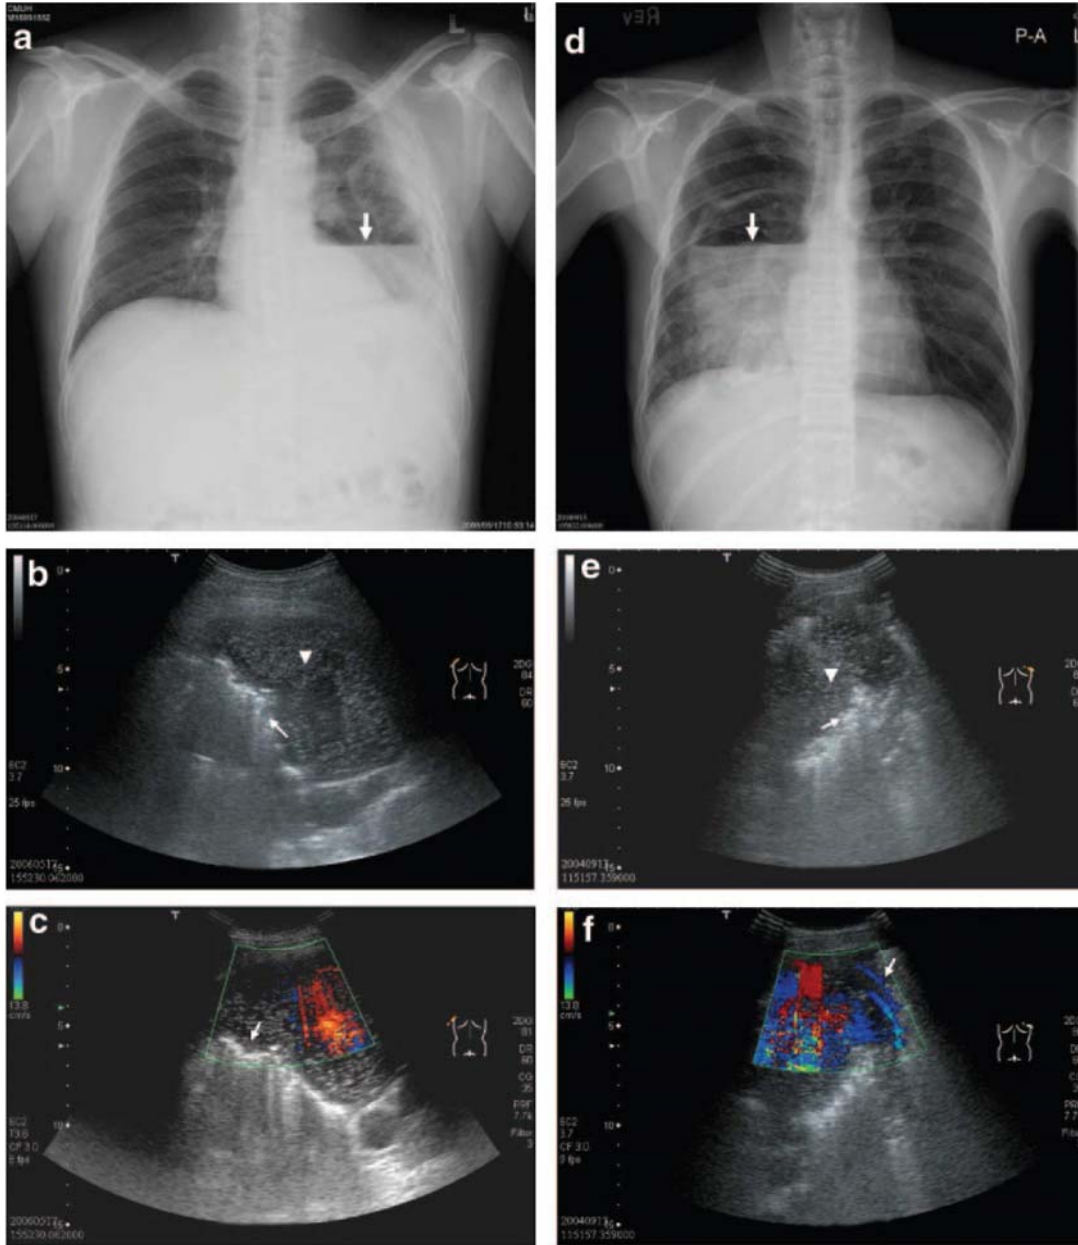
Top left, a, to bottom left, c: empyema. Top left, a: radiograph of the chest of a 43-year-old man shows an air-fluid level (arrow) in the left lower lobe. Middle left, b: grayscale ultrasound examination reveals a hypoechoic lesion with suspended microbubble sign (arrowhead), irregular wall width, and irregular luminal and outer margins (arrow). The sonographic characteristics favored lung abscess. Bottom left, c: color Doppler ultrasound, however, could not identify vessel signals in pericavitary lesion (arrow), which is the typical finding of empyema. Top right, d, to bottom right, f: abscess. Top right, d: radiograph of the chest of a 37-year-old man shows an air-fluid level (arrow) in the right lower lobe. Middle right, e: grayscale ultrasound examination reveals a hypoechoic lesion with suspended microbubble signs (arrowhead), irregular wall width, and irregular luminal and outer margins (arrow). The sonographic characteristics favored lung abscess. Bottom right, f: color Doppler ultrasound also could identify vessel signals in pericavitary consolidation (arrow).
